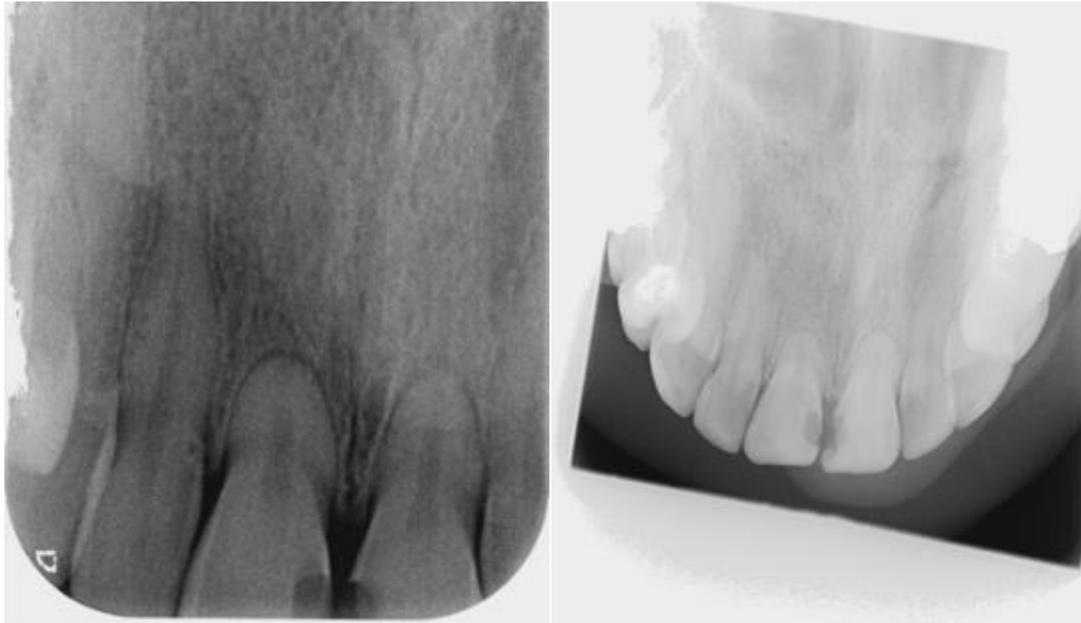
Periapical radiograph of UR2, UR1, UL2. Fig. 3 Upper occlusal radiograph of UR2- UL2
